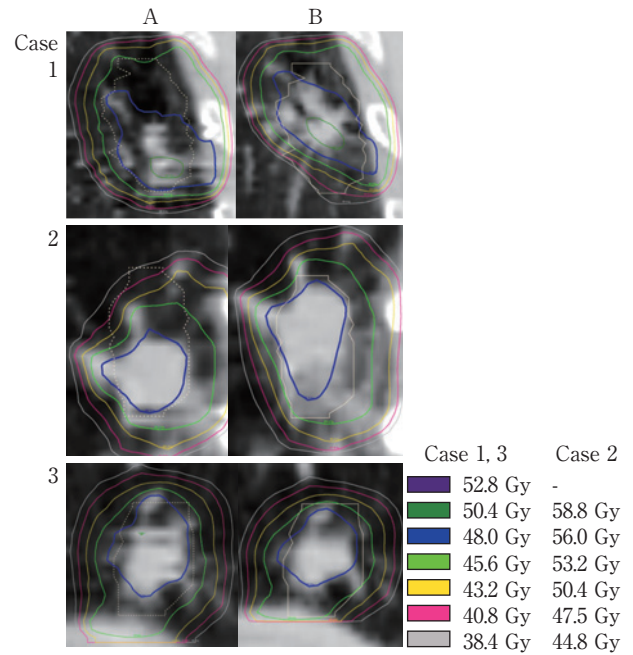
Dose distributions for cases 1 through 3. All CT images are coronal views.
